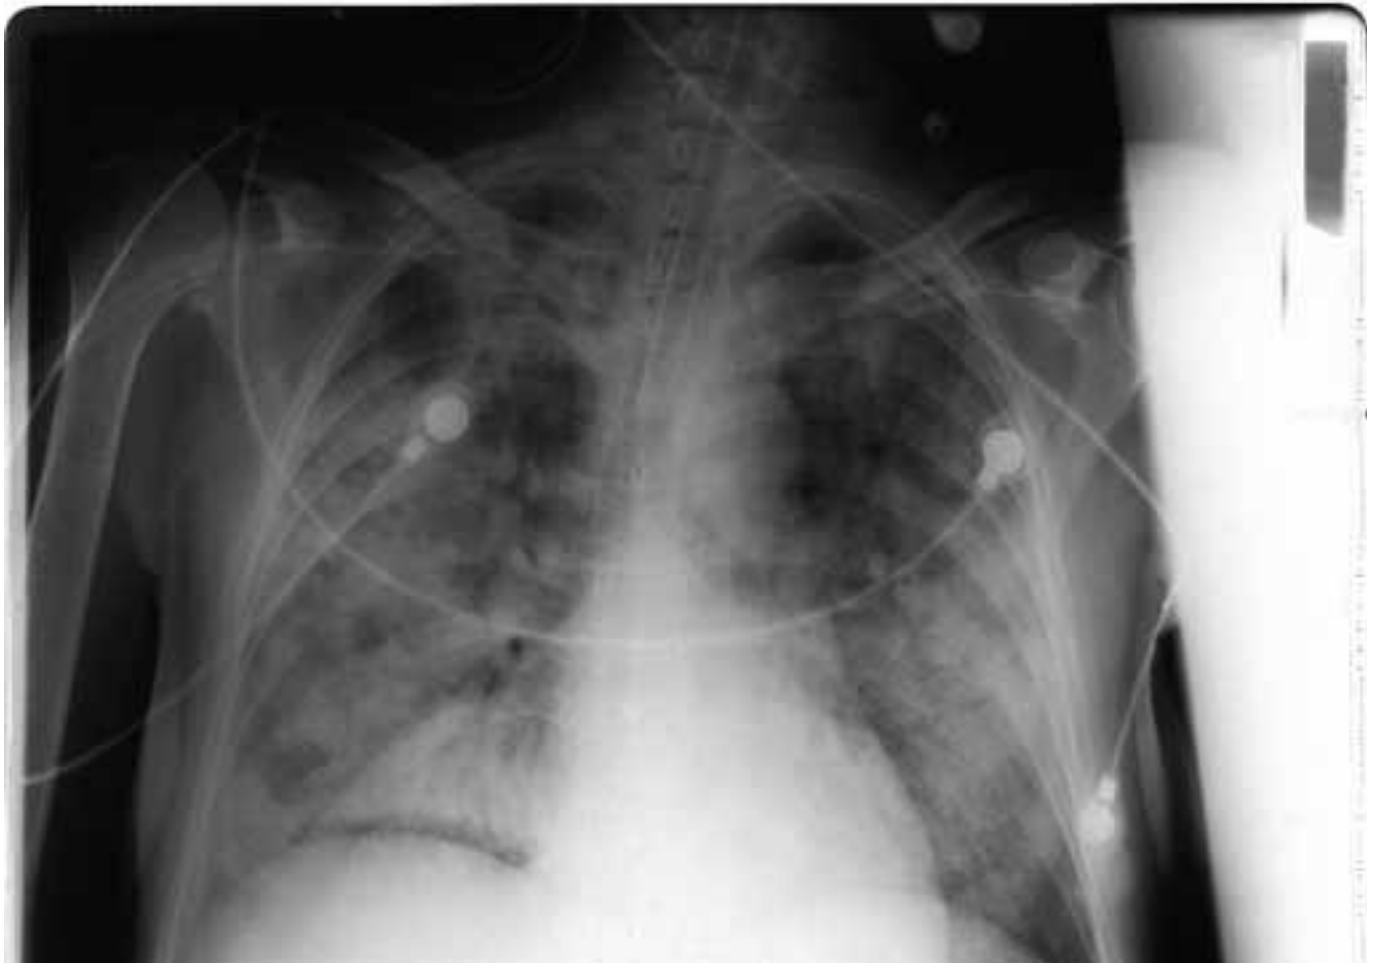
X-ray image showing central venous catheter advanced from the basilic vein with tip lying deeply in the right atrium
